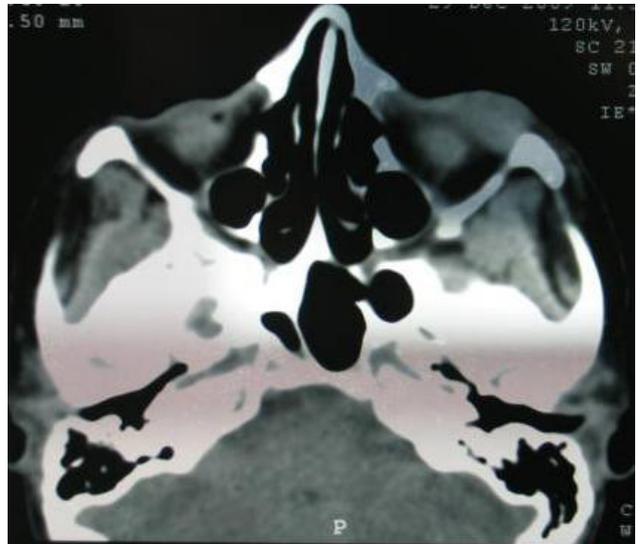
CT scans of a schwannoma demonstrate the well-defined extraconal tumor.
